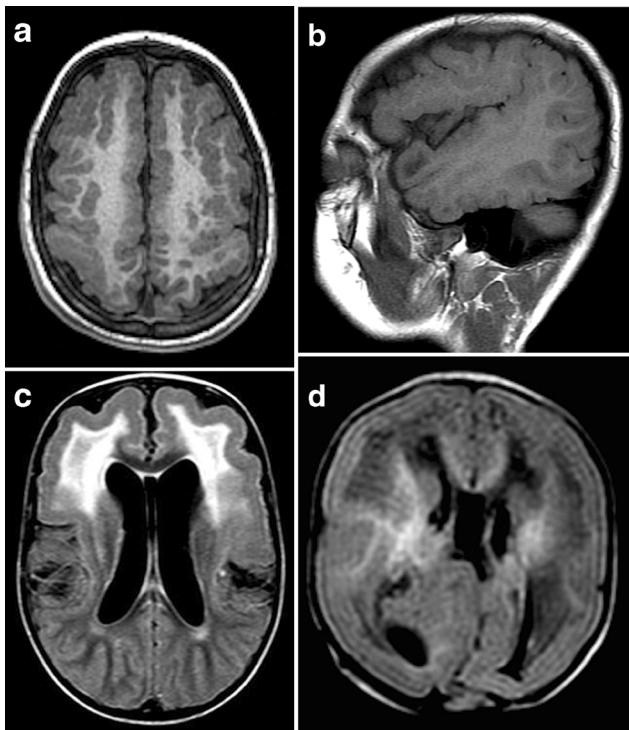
MR images reveal patterns of cortical abnormalities. a–b A 7-year-old boy with congenital CMV. Axial and sagittal pre-gadolinium-enhanced T1-weighted images demonstrate frontal and perisylvian polymicrogyria. c A 4-year-old girl with MCD. An axial FLAIR image demonstrates frontal pachygyria and bilateral frontal white matter hyperintensity. d A 3-month-old boy with MCD (Walker–Warburg syndrome). Axial FLAIR images demonstrate lissencephaly and a diffuse white matter impairment
